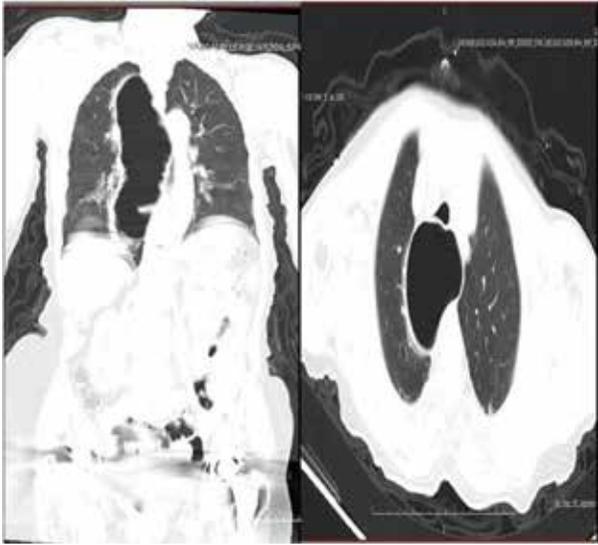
Images of the coronal and axial thorax CT of the megaesophagus; approximately 7 cm in diameter.
